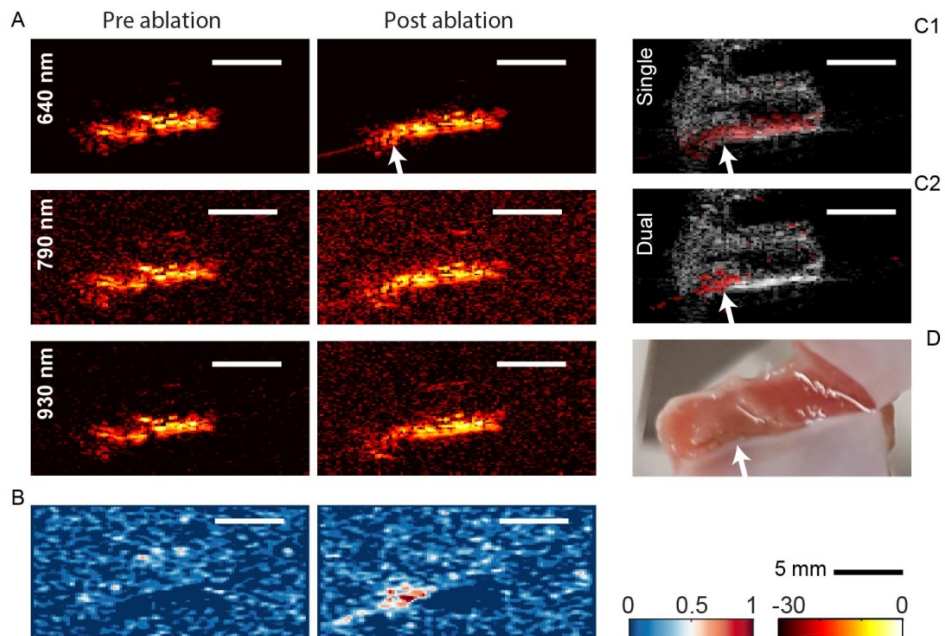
A. Pre- and post-ablation PA images of a tissue sample at 640, 790 and 930 nm. B. Dual wavelength images pre- and post-ablation. C. Single wavelength (C1) and dual wavelength (C2) images overlaid on ultrasound. D. Photo of the tissue sample. The arrow points at the ablation site.
